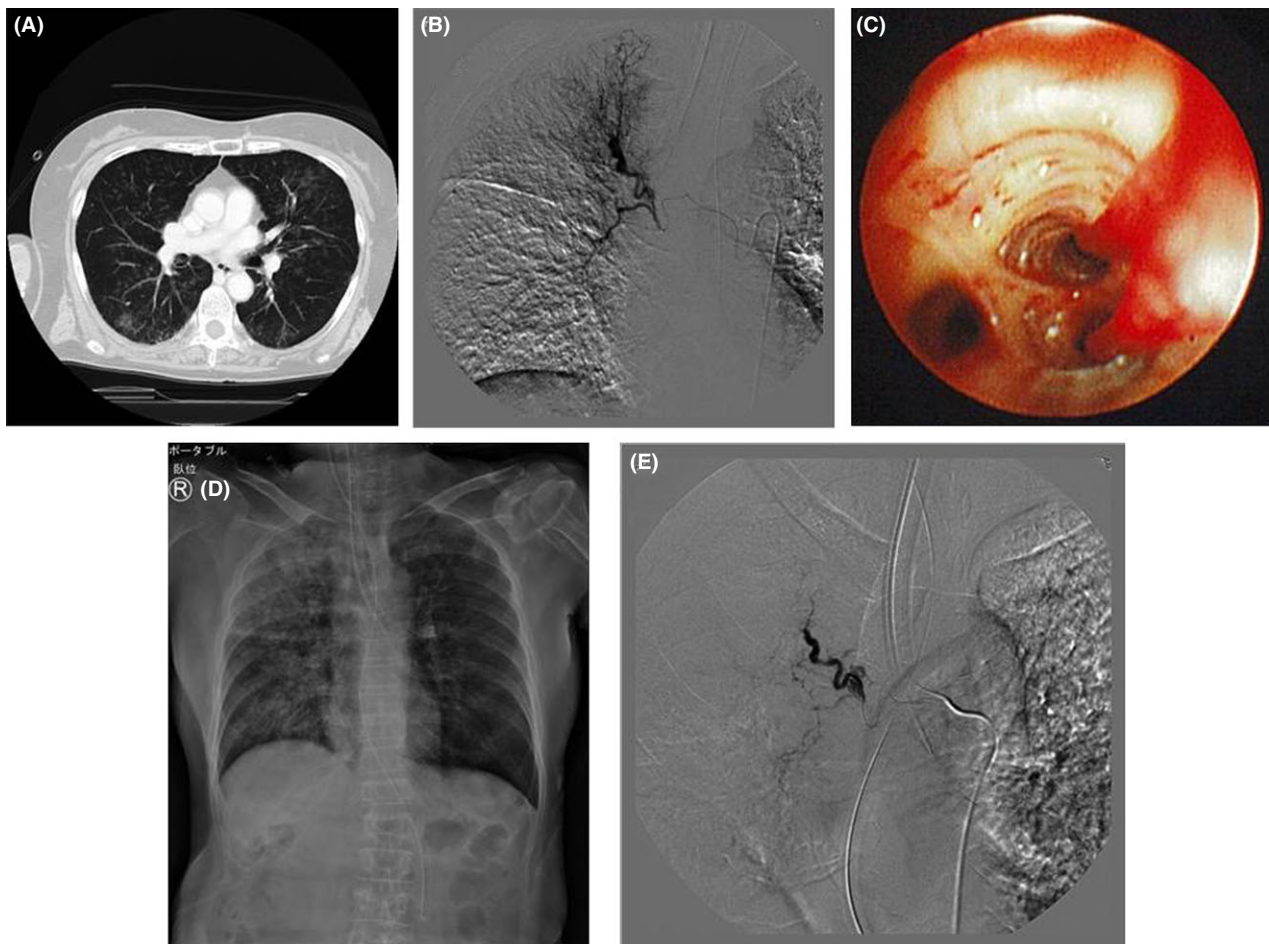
A, Computed tomography findings in a 63-year-old woman at admission revealed an infiltrative shadow in the right lung field. B, Bronchial angiography showed dilatation >2 mm on the proximal side of the right main bronchial artery and diffuse angiectasis >0.5 mm on the distal side. C, Bronchoscopic findings showed massive blood clots in the right main bronchus. D, The day after admission, the patient suffered massive hemoptysis triggered by coughing and severely poor ventilation caused by asphyxia. One-lung ventilation was obtained by temporarily inserting an endotracheal tube into the left main bronchus to secure ventilation. E, Following emergency bronchial angiography, the culprit vessel was detected by use of a microcatheter. Bronchial artery embolization was carried out.
